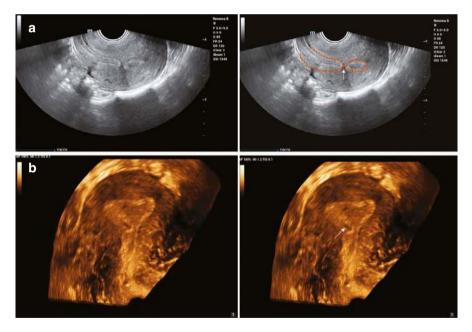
(a) Type I IUA, showing discontinuous endometrial echogenicity and an irregular hypoechoic band at the site of the discontinuity. The endometrium is circled in orange, and the arrow points to the hypoechoic zone. (b) A case of Type I IUA, with adhesion bands visualized on the coronal plane of 3D ultrasound. The arrow indicates an adhesive band
